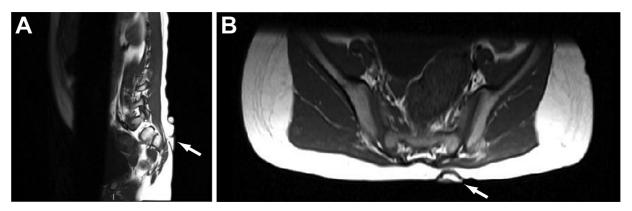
T1 axial and sagittal magnetic resonance imaging (MRI) images of the lumbosacral appendage. (A) Axial and (B) sagittal.
